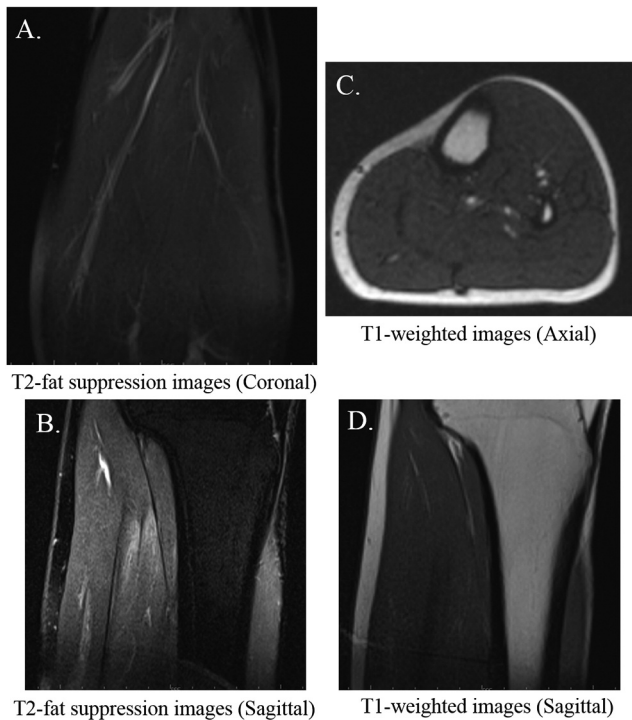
A coronal view (A) and sagittal view (B) of T2-fat suppression magnetic resonance (MR) images. An axial view (C) and sagittal view (D) of T1-weighted MR images.
